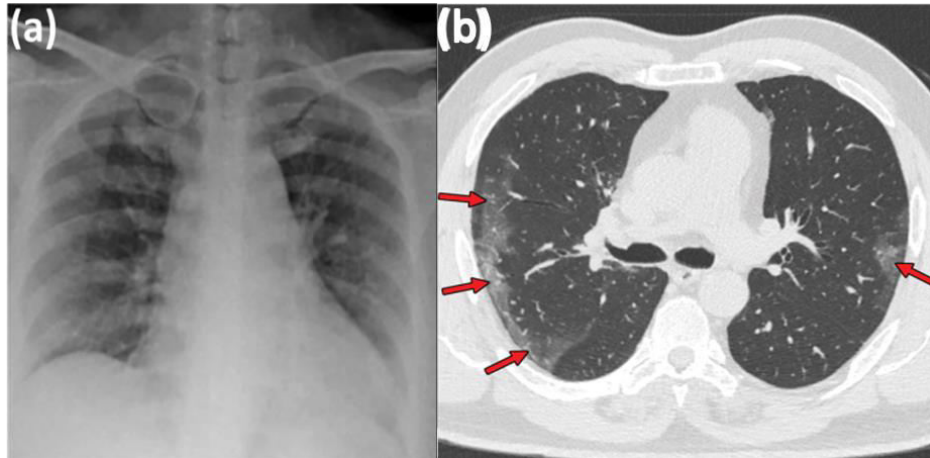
(a) Chest X-Ray [16] and (b) CT images of COVID-19 cases [26].
